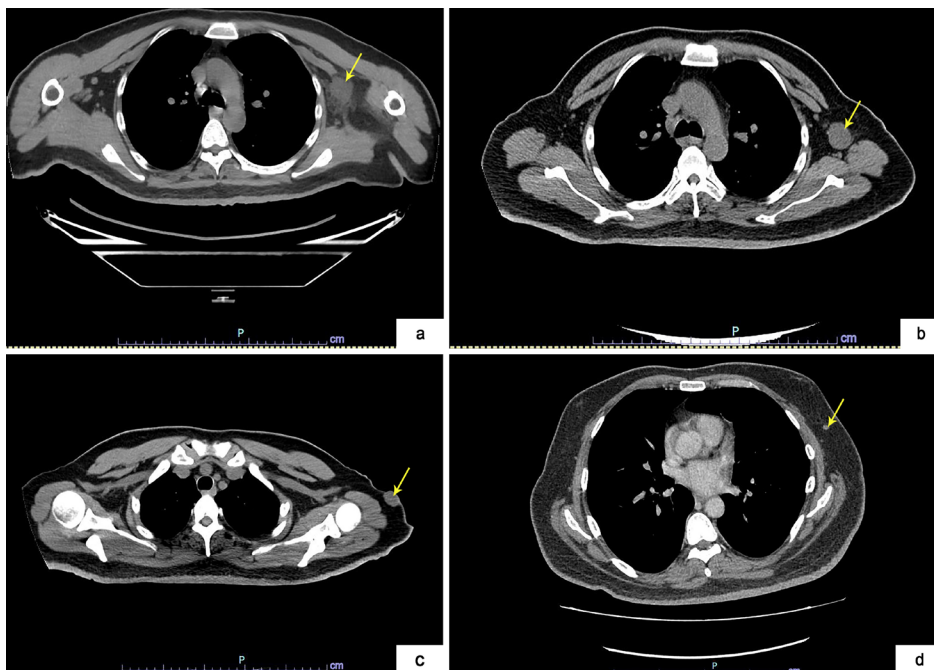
CT images showed lesions at (a) Left axillary node; (b) Left axillary node; (c) left axillary skin lesion (d) Small left breast nodule
